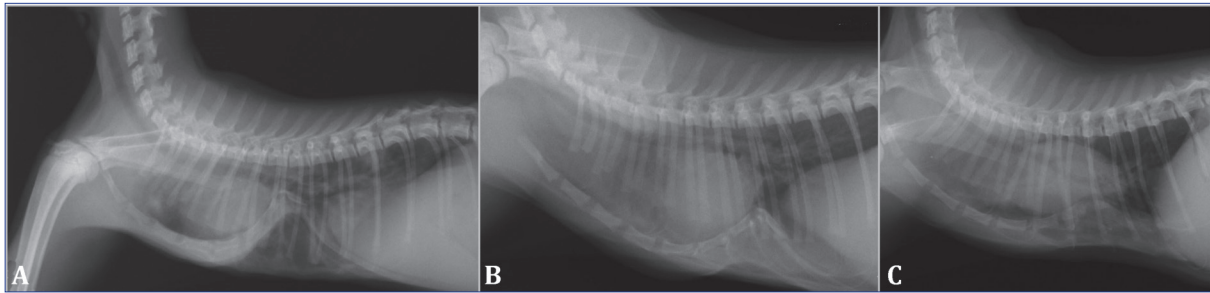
Case no: 4. Preoperative radiography, A; One week after removal of external splint, B; One month after second external splint application, C
